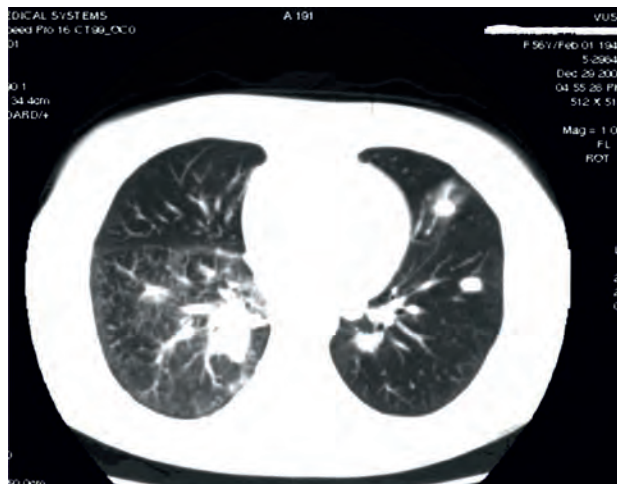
A chest CT scan (December 29, 2005) revealing soft tissue mass 35×34 mm in size and uneven polycyclic contour with centralization in segment VI of the right lung
